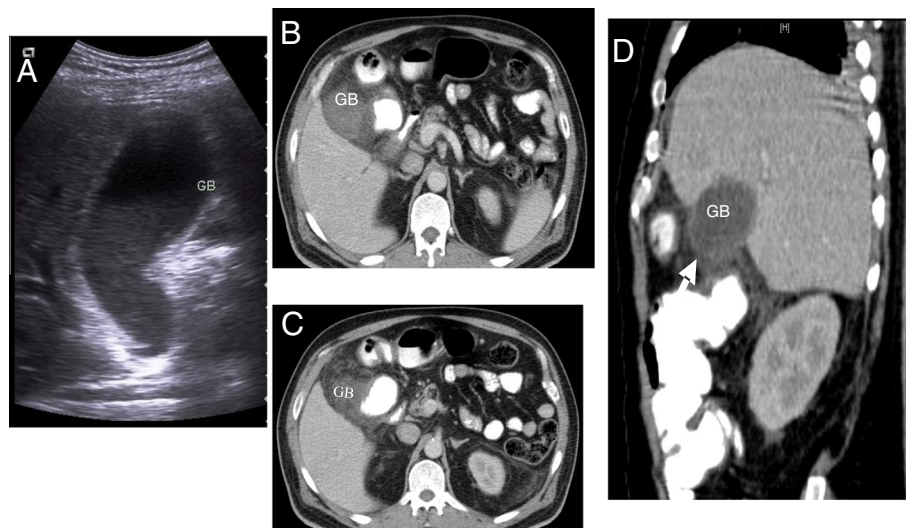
56-year-old male has DM, HTN, and IHD presented with acute abdominal pain especially over RUQ associated with spikes of fever. a Admission US shows relative GB distension with biliary mud (bile-mud level). There were no stones or pericholecystic fluid. The patient did not improve on conservative treatment and pain was increasing. 40 h later, CT scan done, axial (b, c) and 2D sagittal reformat (d) shows lack of enhancement of GB wall, pericholecystic fluid collection, and inflammatory changes in juxtaposed hepatic flexure of colon. GB wall was not clearly identified at the fundus (arrow in d). Laparoscopic cholecystectomy revealed a gangrenous GB filled with pus (acute non-calicular empyema and gangrenous GB)
